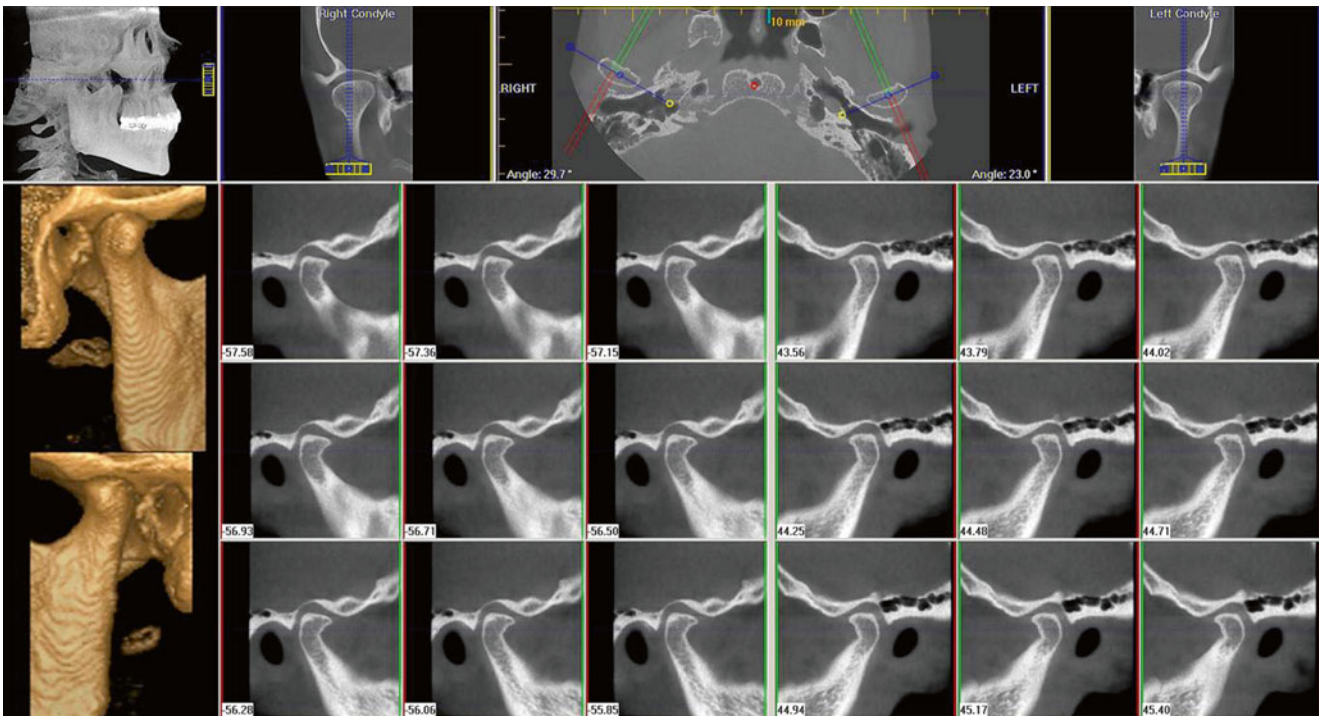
Cross-sectional depiction of the osseous components of the TMJ as generated from a CBCT scan
